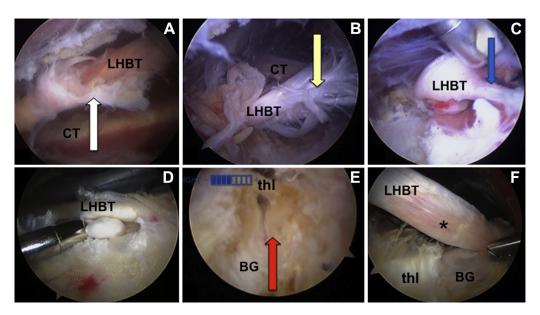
Several abnormal lesions were identified in the fibro-osseous extra-articular segment of the long head of the biceps tendon (LHBT) from within the subdeltoid space during arthroscopic transfer of the LHBT to the conjoint tendon (CT), despite a normal intra-articular arthroscopic examination. Representative examples included (A) scarring (white arrow), (B) partial tearing (yellow arrow), (C) symptomatic vincula (blue arrow), (D) loose bodies, (E) bony stenosis of the bicipital groove (red arrow), and (F) instability characterized by a shallow broad osseous floor, gossamer transverse humeral ligament (thl), and resulting irritation of the LHBT (asterisk). (BG, bicipital groove.)
